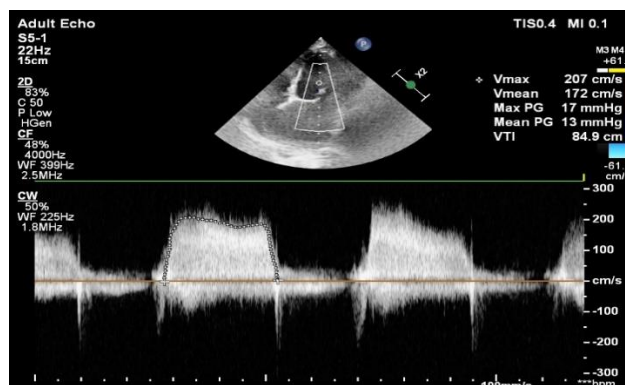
Trans-mitral spectral Doppler showing peak velocity, peak and mean gradients measurement.
